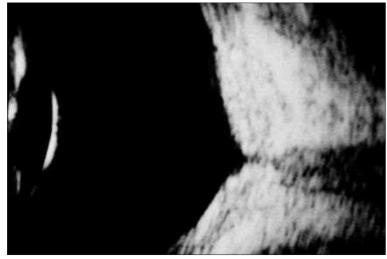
Axial B-Scan Ultrasound Image of an Eye With Diffuse Choroidal Hemangioma Showing Generalized, Moderately Sonoreflective Thickening of the Posterior Choroid and Deep Focal Posterior Pit Corresponding to Optic
